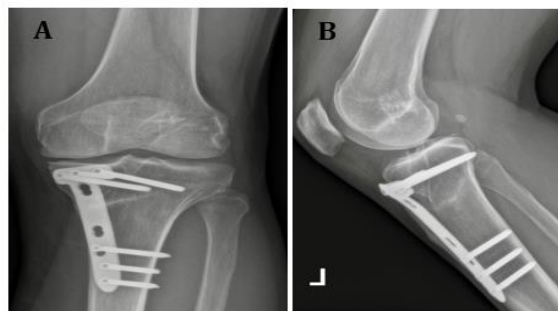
(A-B): Postoperative radiographs of a patient with anterior cruciate ligament (ACL) chronic deficiency and varus osteoarthritis. He underwent simultaneous hamstring autograft ACL reconstruction (ACLR) and medial open-wedge high tibial osteotomy (MOW-HTO): (A) anteroposterior radiograph; (B) lateral view
